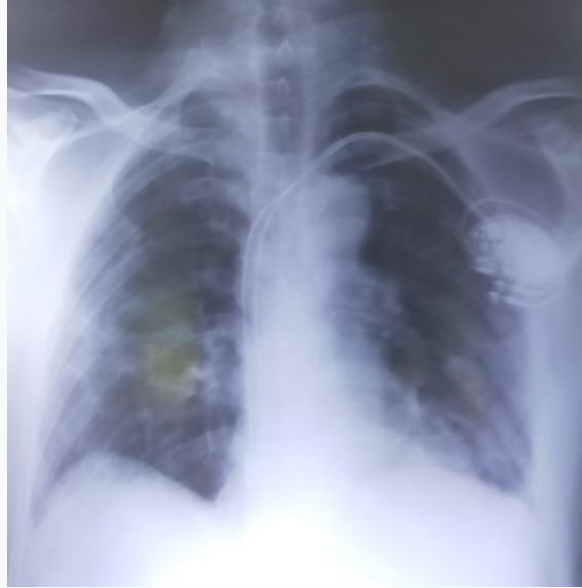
chest X-ray and chest CT scanner of the second patient after pace maker implantation
